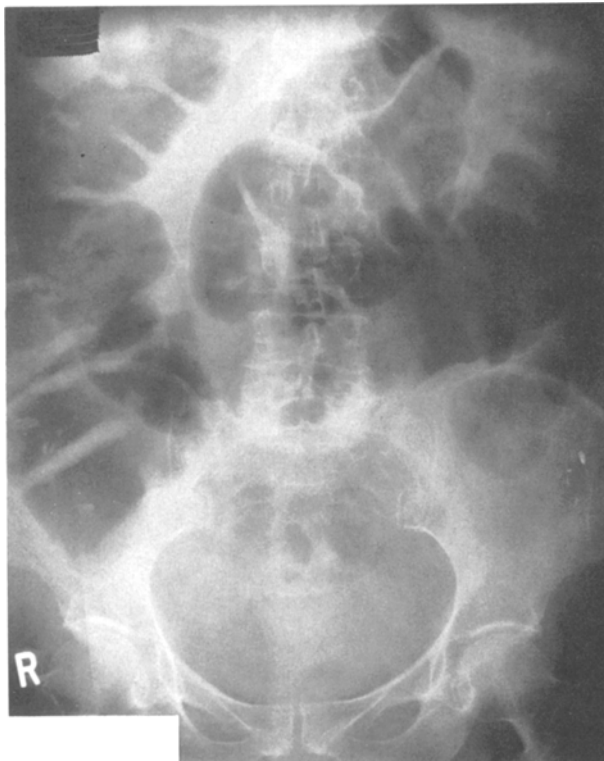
Abdominal radiograph taken on hospital day two demonstrates recurrent large bowel obstruction.
